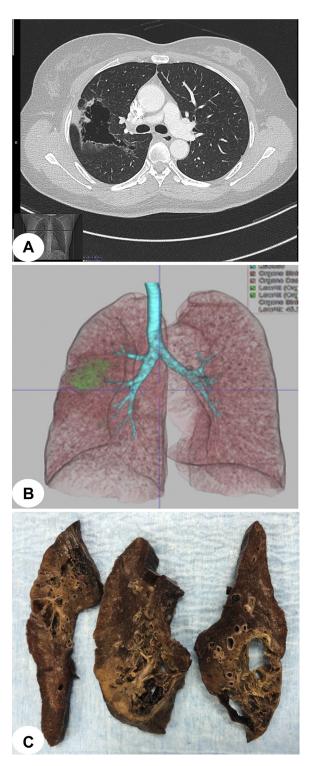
Computed tomography scan examination revealed a large cystic lesion with infiltrated margins of the right upper and middle lobes (A). Three-dimensional reconstruction confirmed a cystic lesion abutting the visceral pleura (B). Gross preparation of the lung showed an irregular, anfractuous and multilocular cyst with margin infiltration but predominant dilation due to air trapping (C).
